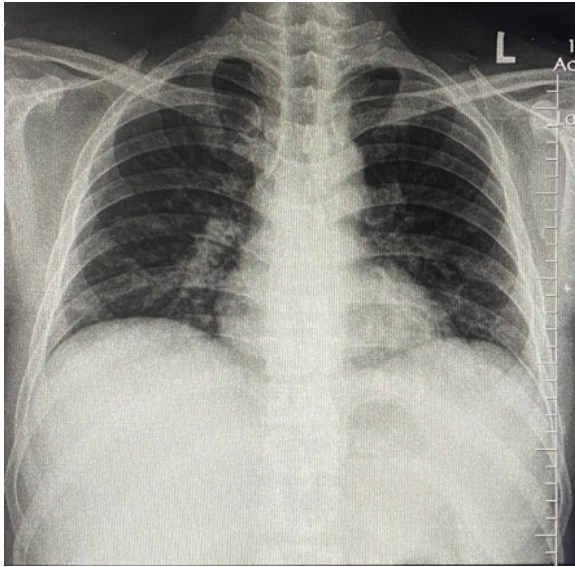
Radiograph of patient in day 1.
